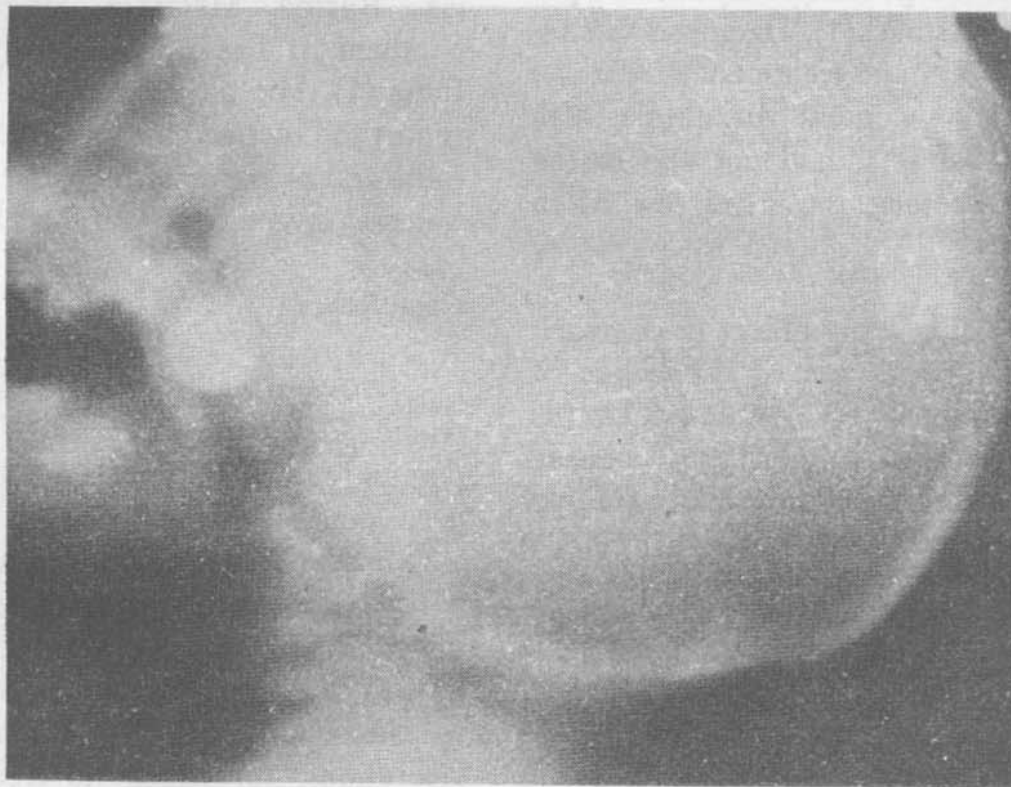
X-ray nasopharynx (lateral view) showing marble in nasopharynx.
